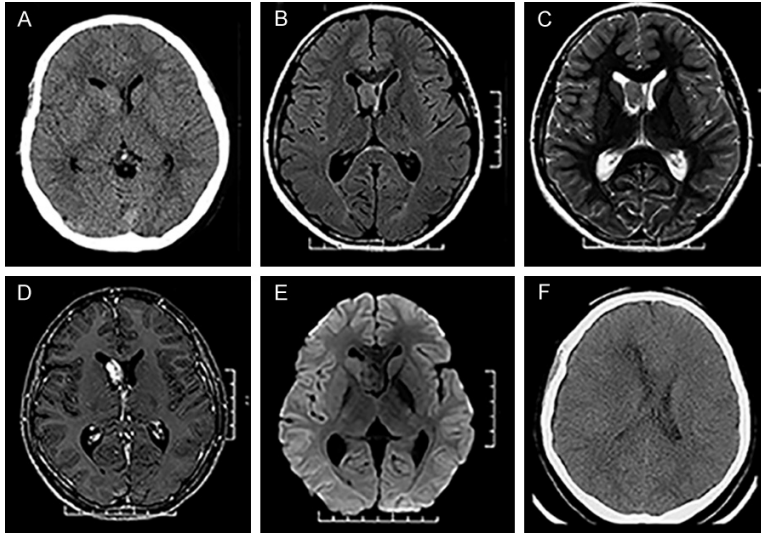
Radiological profiles of the boy with chordoid glioma. Brain CT scanning showed an ill-defined isodense mass in the right frontal horn of lateral ventricle (A). Brain MRI revealed a nodular mass in the right frontal horn of lateral ventricle, which appeared slight hyperintensity on T1-weighted imaging (B) and slight hyperintensity on T2-weighted imaging (C). After administration of contrast medium, heterogeneously remarkable enhancement was observed (D). The tumor was isointensity on diffusion-weighted imaging (E). The follow-up CT 6 months after surgery showed no recurrence (F).
